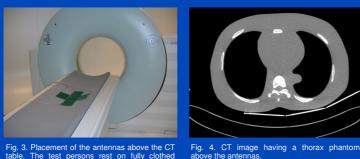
Placement of the antennas above the CT table. The test persons rest on fully clothed directly above the antennas.
